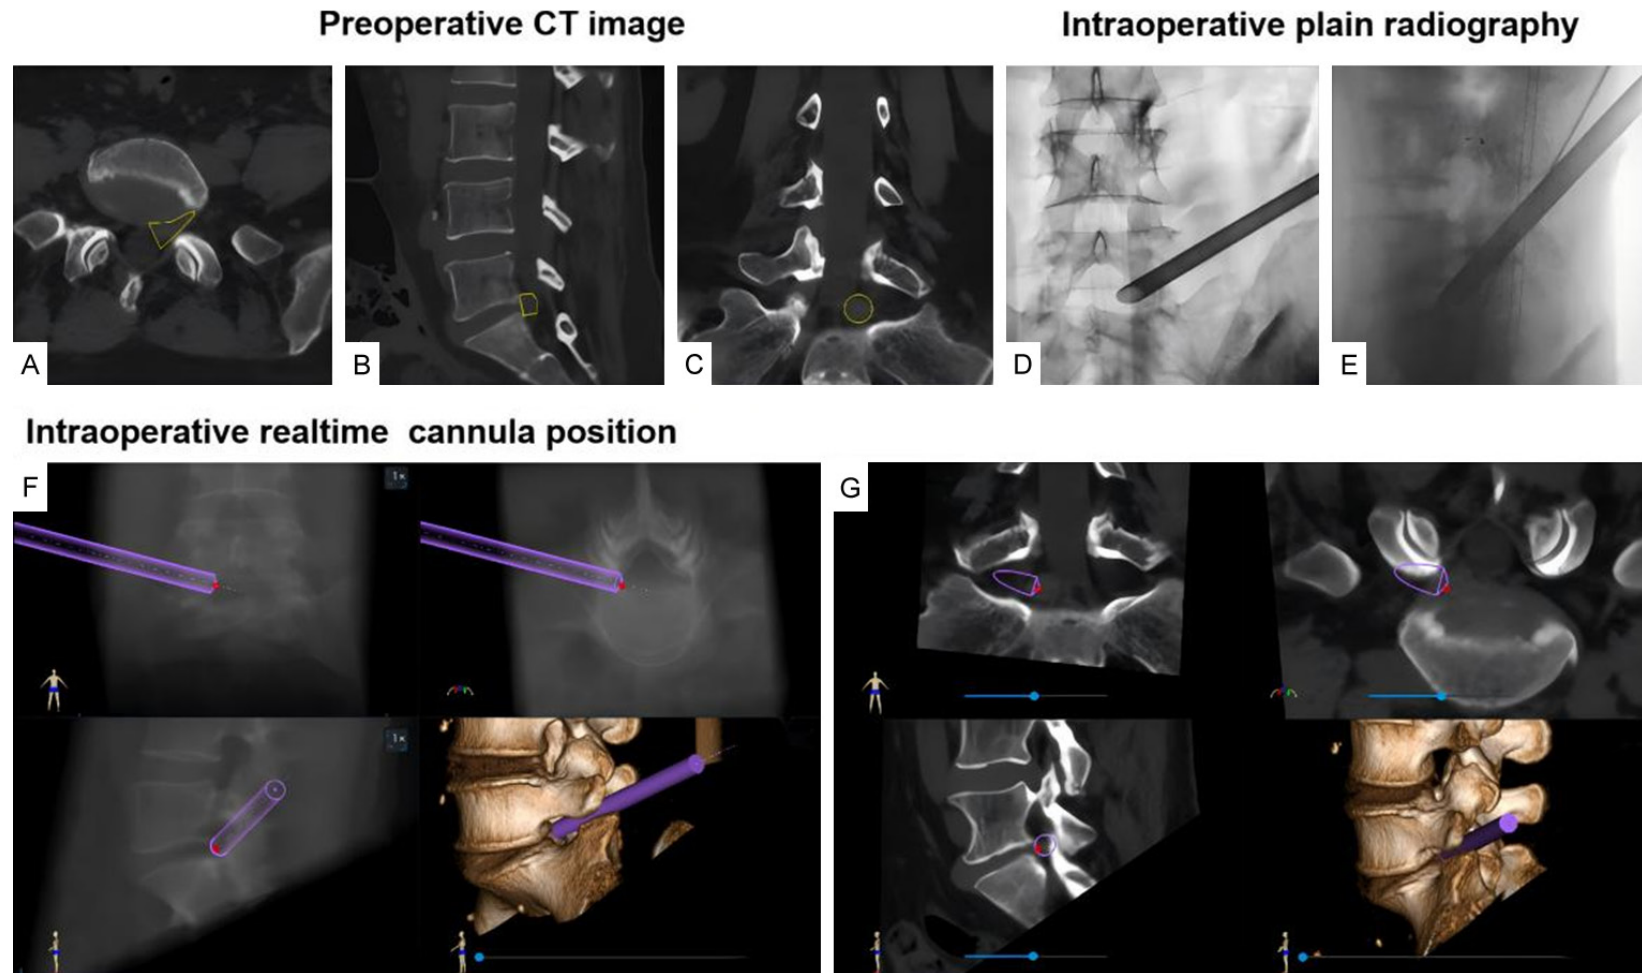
Working principle of the spinal surgery navigation and positioning system in measuring distance. A-C. Preoperative CT images showing the target intervertebral foramen and planned working channel trajectory in axial, sagittal, and coronal planes. D, E. Intraoperative plain radiographs confirming the initial trajectory of the guiding needle and working cannula placement. F, G. Real-time intraoperative navigation display demonstrating the virtual trajectory of the working cannula in multiple planes and 3D reconstruction.
